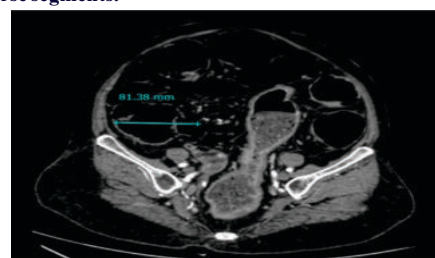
CT Abdomen - Marked distension of the entire large bowel from caecum to rectosigmoid with cecal diameter measuring 8.1 cm in transverse diameter.
